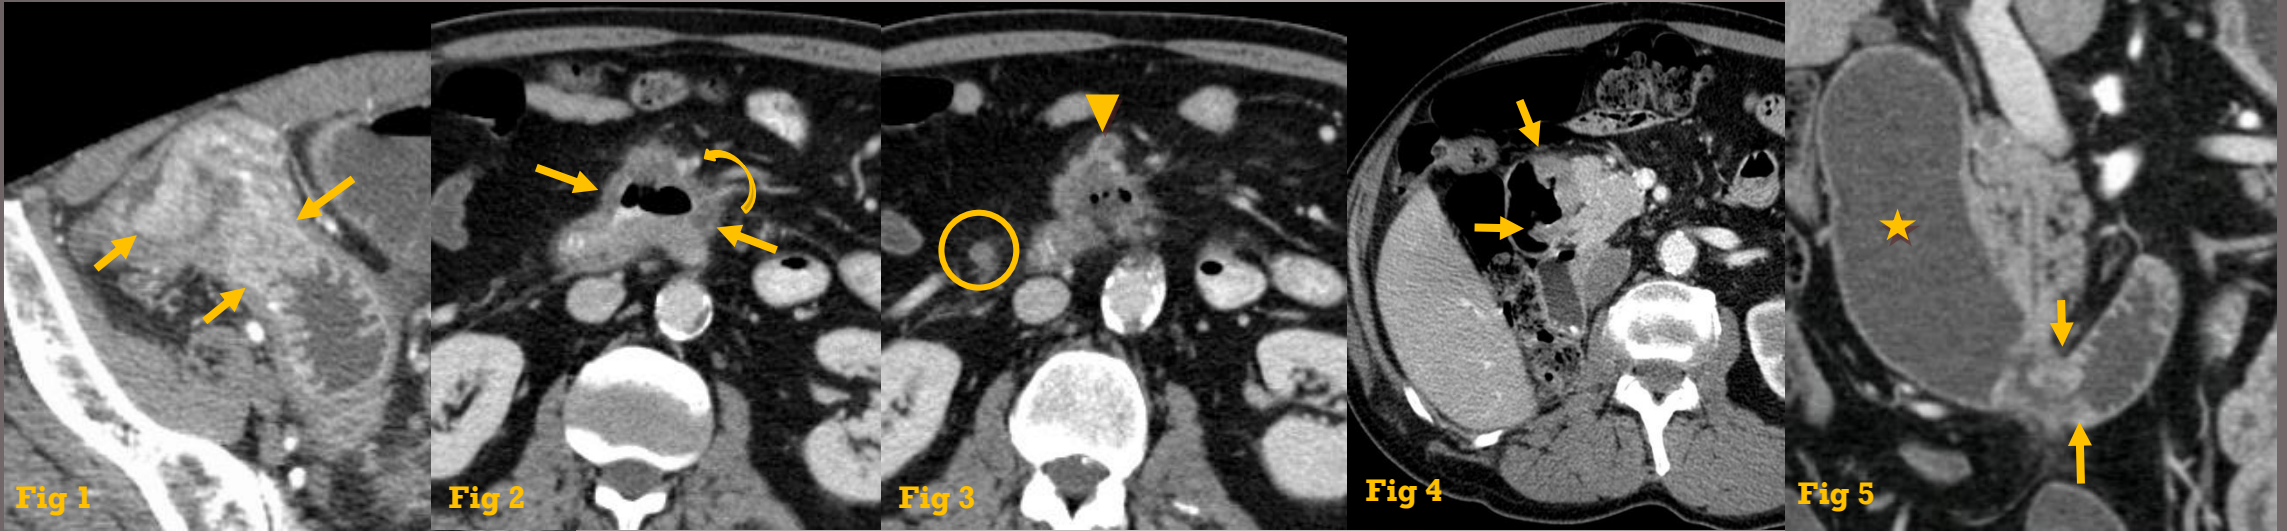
Abdominal CT of a patient with an adenocarcinoma of the ileum that extended to the ileocecal valve shows focal irregular thickening with enhancement of the terminal ileum (arrows). Note absence of mesenteric inflammatory signs.
